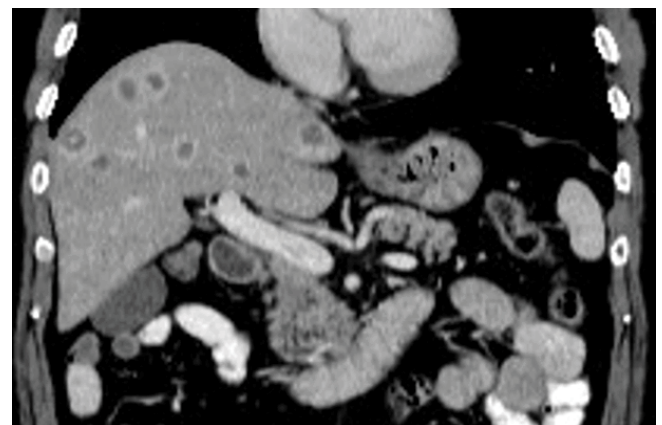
Baseline CT scan on May 25th, 2025, showing multiple bilobar rim-enhancing lesions in the liver representing multifocal malignancy sites.
